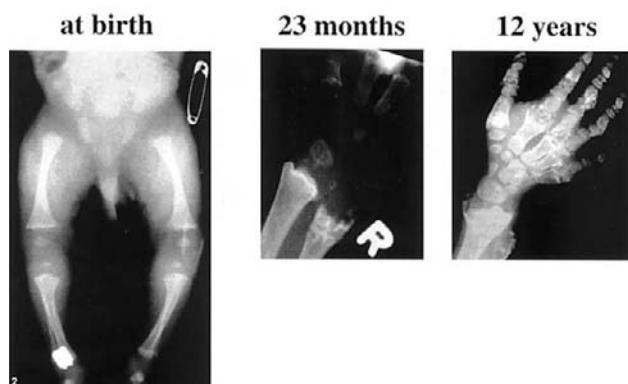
A patient with Jansen's disease and his radiological findings at different ages. (A) Patients with Jansen's metaphyseal chondrodysplasia (from Jansen, 1934, De Haas *et al.*, 1969; Silverthorn *et al.*, 1983); photograph of the latter patient kindly provided by Drs. Kooh and Cole, Hospital for Sick Children, Toronto, Canada). (B) X-rays from a patients with Jansen's disease at birth, 23 months, and 12 years of age. From Silverthorn *et al.* (1983), with permission.
